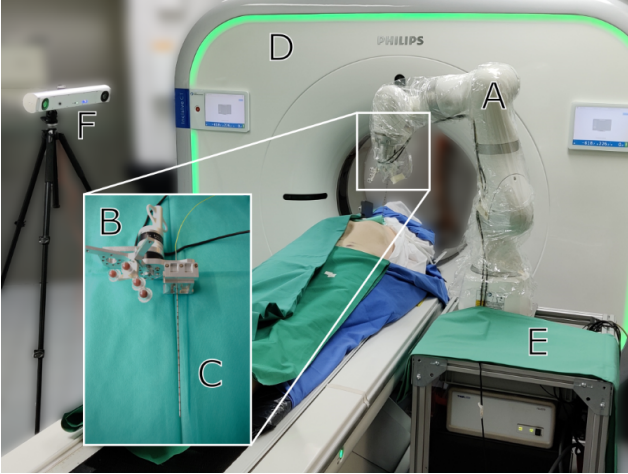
Collaborative Robotic System: The experimental setup consists of the robot (A), the needle mount (B) with integrated force sensors and tracking markers, the *smart* needle (C), the CT system (D), the robot cart (E) with the built-in OCT system and the optical tracking system (F).
